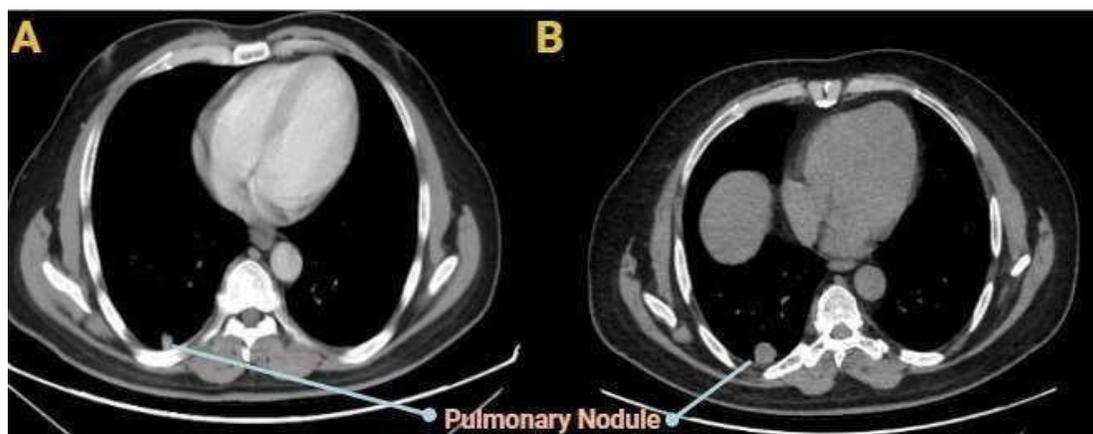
Interval Progression of Pulmonary Metastases on CT Imaging
